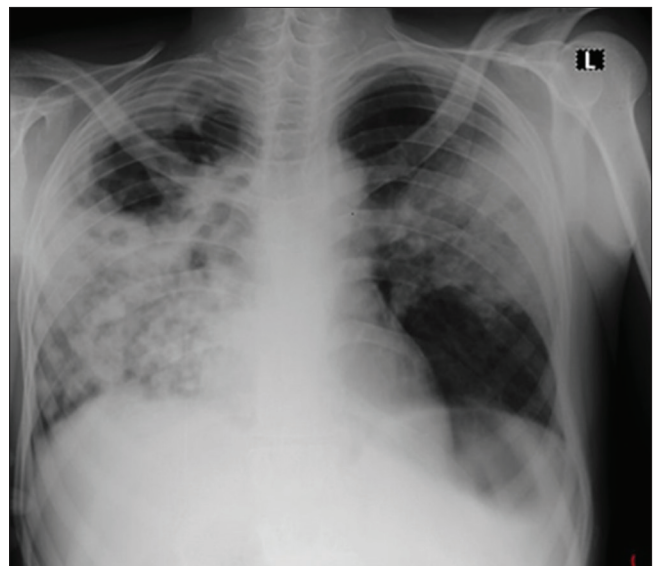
Radiographic changes in patient two
